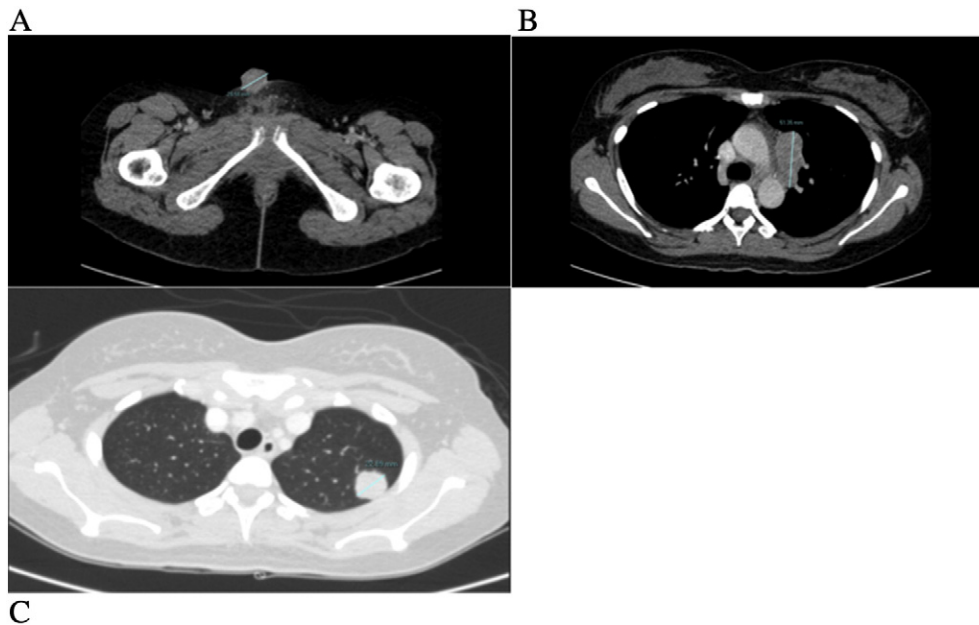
Post tandem autologous SCT, progressive disease on restaging CT Chest/Abdomen/Pelvis. 3A: vulvar primary; 3B: left mediastinal nodal mass; 3C: left upper lobe – lung.
